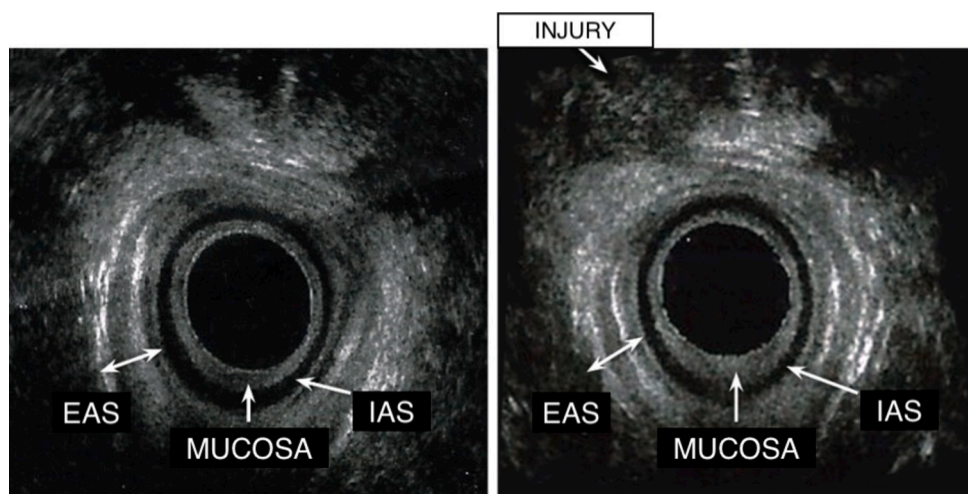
Endoanal ultrasound before (left image) and after episiotomy, done at a 40–50 degree angle to the midline (right image) – injury to anal sphincter visible (Injury: injury of the external anal sphincter; Mucosa: Anal Mucosa; EAS: external anal sphincter; IAS: internal anal sphincter).
